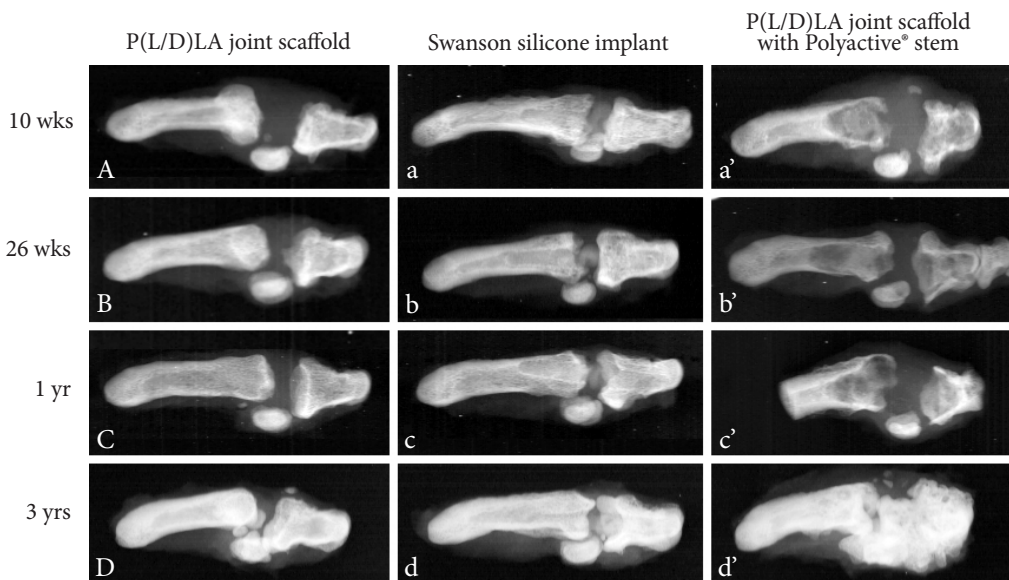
Radiographs of the arthroplasty after P(L/D)LA 96/4 joint scaffold, Swanson silicone implant and P(L/D)LA 96/4 joint scaffold with a Polyactive® 1000PEO70PBT30 stem in lateral projection examined post-operatively at 10 weeks, 26 weeks, 1 year and 3 years. On the left metacarpal bone and on the right proximal phalanx in each radiograph.
